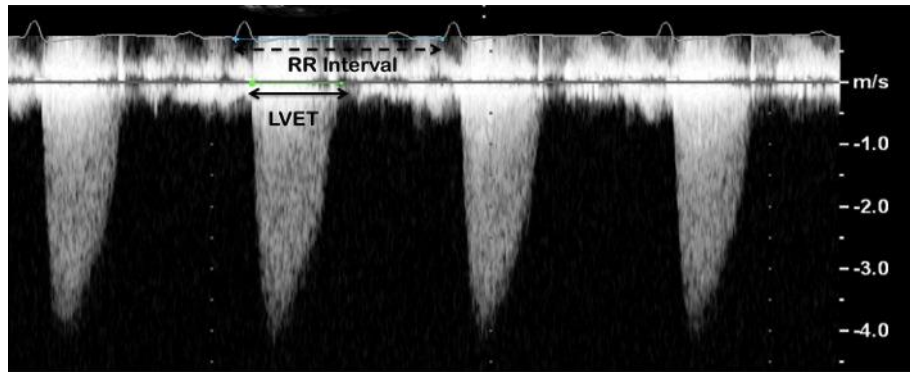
Measurement of left ventricular ejection time (LVET) and RR-interval on a continuous wave doppler across the aortic valve.
